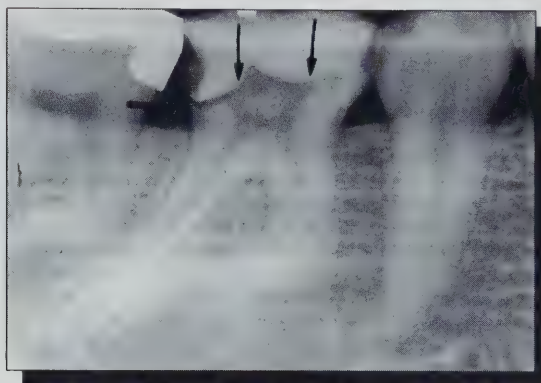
A radiograph of a clinical example of an error in mandibular molar access opening shows that it has been prepared too shallow and has breached the pulp horns only (arrows). Also apparent is leakage on the distogingival margin because all carious dentin was not removed.
